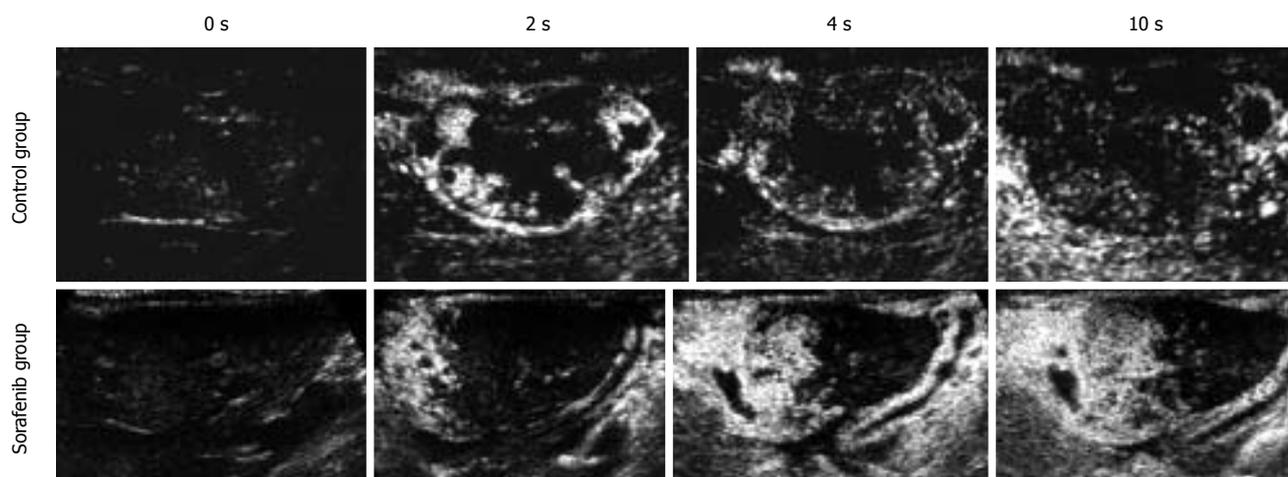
Contrast-enhanced ultrasonography examination showed that time to peak intensity was delayed in the sorafenib-treated group.
